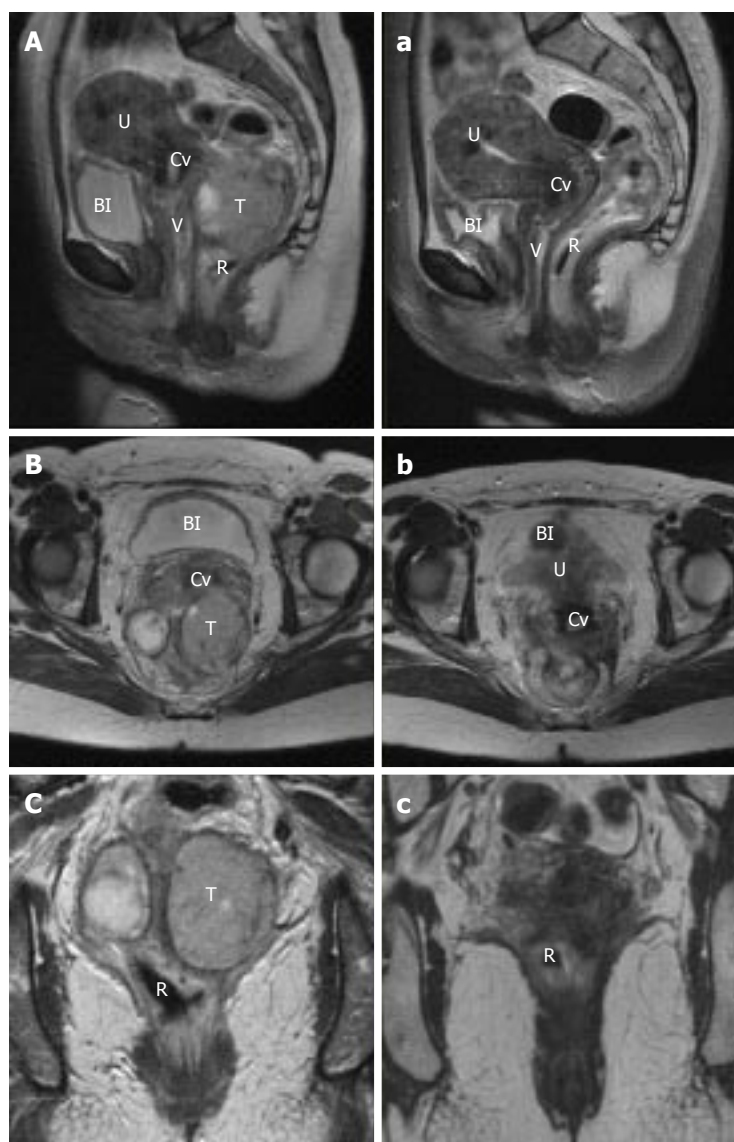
Magnetic resonance imaging appearance of rectal squamous cell carcinoma. Pre (A, B, C) and post (a, b, c) treatment T2 magnetic resonance imaging in sagittal (A, a), axial (B, b) and coronal (C, c) planes of a large rectal SCC, demonstrating an excellent response. T: Tumour; U: Uterus; V: Vagina; Cv: Cervix; BI: Bladder; R: Rectum; SCC: Squamous cell carcinoma.
